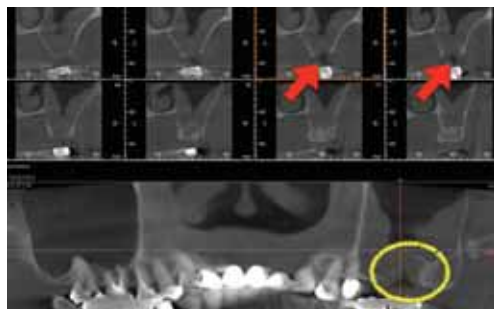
From the CT scan, also bony opening on #27 area and mucosal thickening on left maxillary sinus can be observed. Patient was referred to ENT specialist for examination and medication. Patient was come back after 3 weeks of antibiotics medication.
